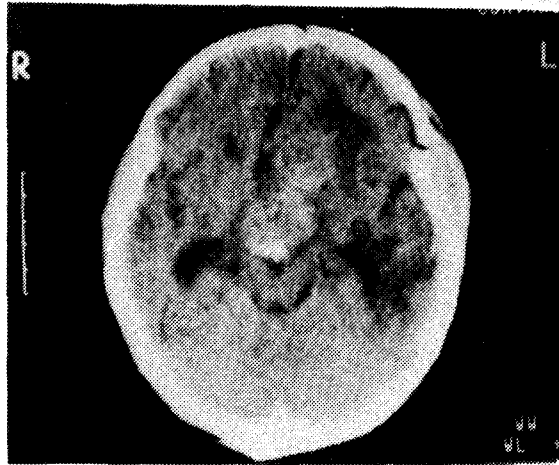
(Ia) : Post contrast CT head scan revealed.
